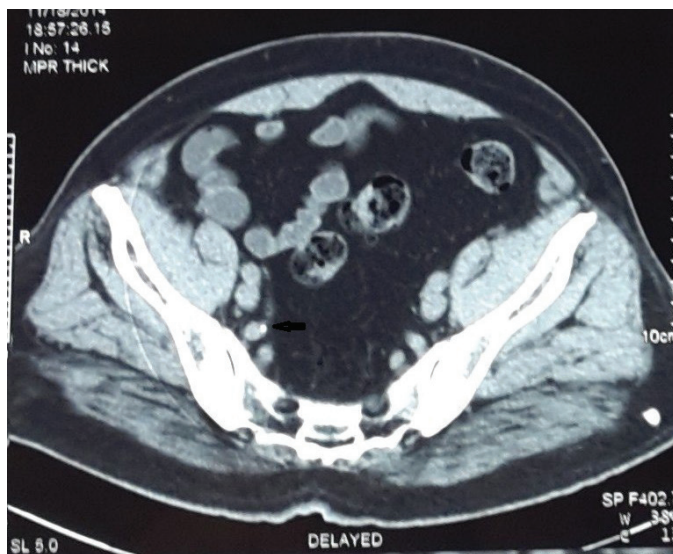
CT Abdomen showing ileal diverticulum with calculi within it.
